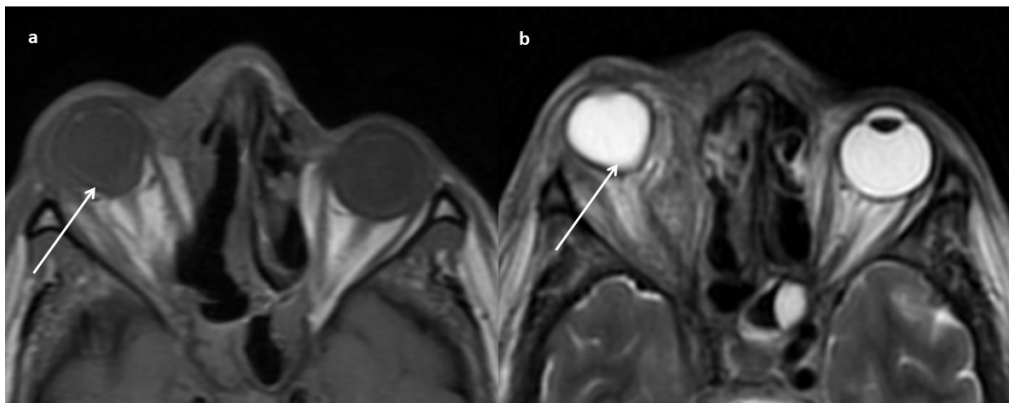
Axial MRI of the orbit (a) T1-weighted (b) T2-weighted show proptosis, stretching of the optic nerve, and tenting of the globe (guitar pick sign) suggestive of orbital compartment syndrome (white arrows).
